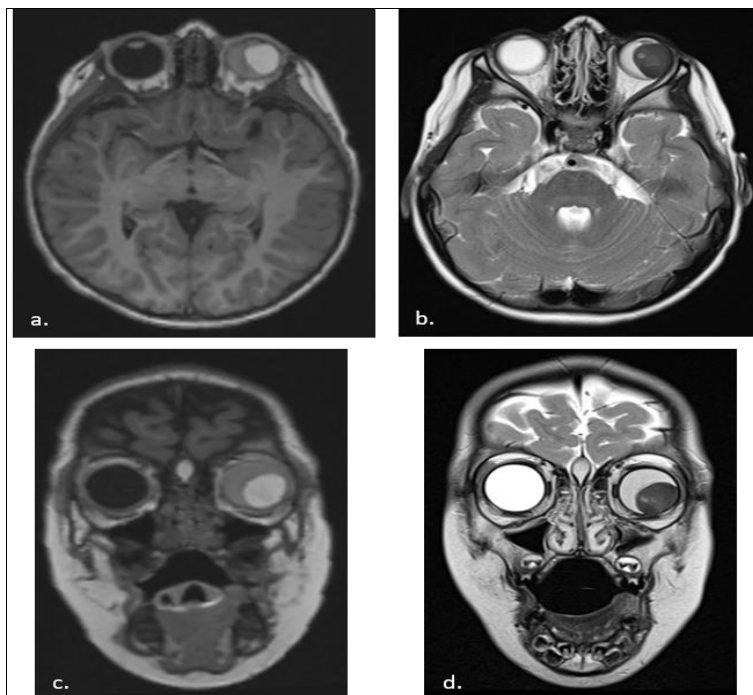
MRI. Left eyeball with evidence of an oval defined lesion at its temporal margin in close contact with the lens, that flattens the posterior sclera and has a subretineal appearance, hyperintense in T1WI, predominantly hypointense in T2WI. Additionally, the vitreous humor in the same eyeball is diffusely hyperintense in T1 and slightly hypointense in T2 highly suggestive of vitreous hemorrhage. a. T1WI axial image. b. T2WI axial image. c. T1WI coronal image. d. T2WI coronal image
